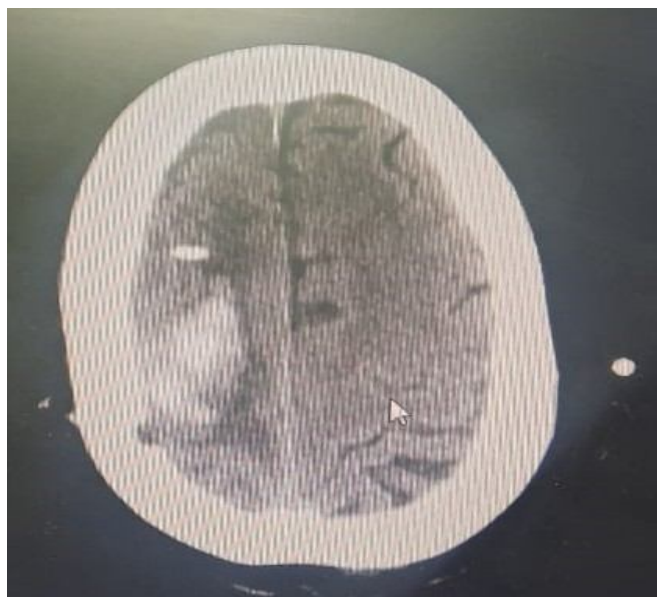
Right parietal lobe intracerebral bleed with interventricular ipsilateral extension in CT scan of brain
